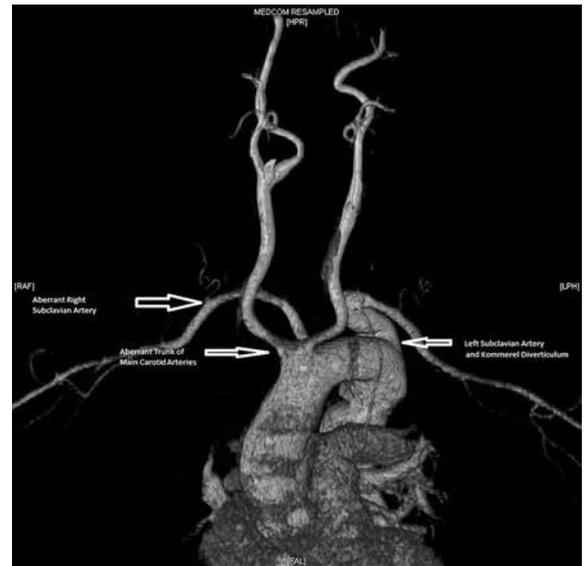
Aorta and arch branches on contrasted computed tomography; anterior sight of three-dimensional reconstruction.
